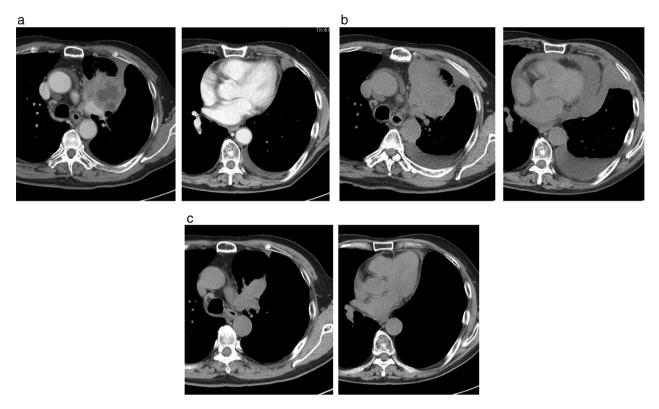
Case 3. (a) Chest computed tomography (CT) showed a tumor in the left upper lobe and pleural effusion emerged before nivolumab treatment was initiated. (b) Three days after the first administration of nivolumab, left-sided pleural effusion and pericardial effusion progressed. (c) After chest and pericardial drainage, a chest CT showed that the lung tumor had reduced, and the left-sided pleural and pericardial effusion did not increase after eight cycles of nivolumab treatment.
